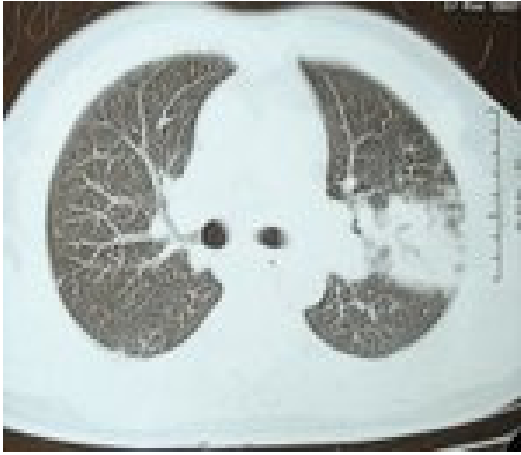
CT scan of chest showed consolidation in apico-posterior segment of left upper lobe.
